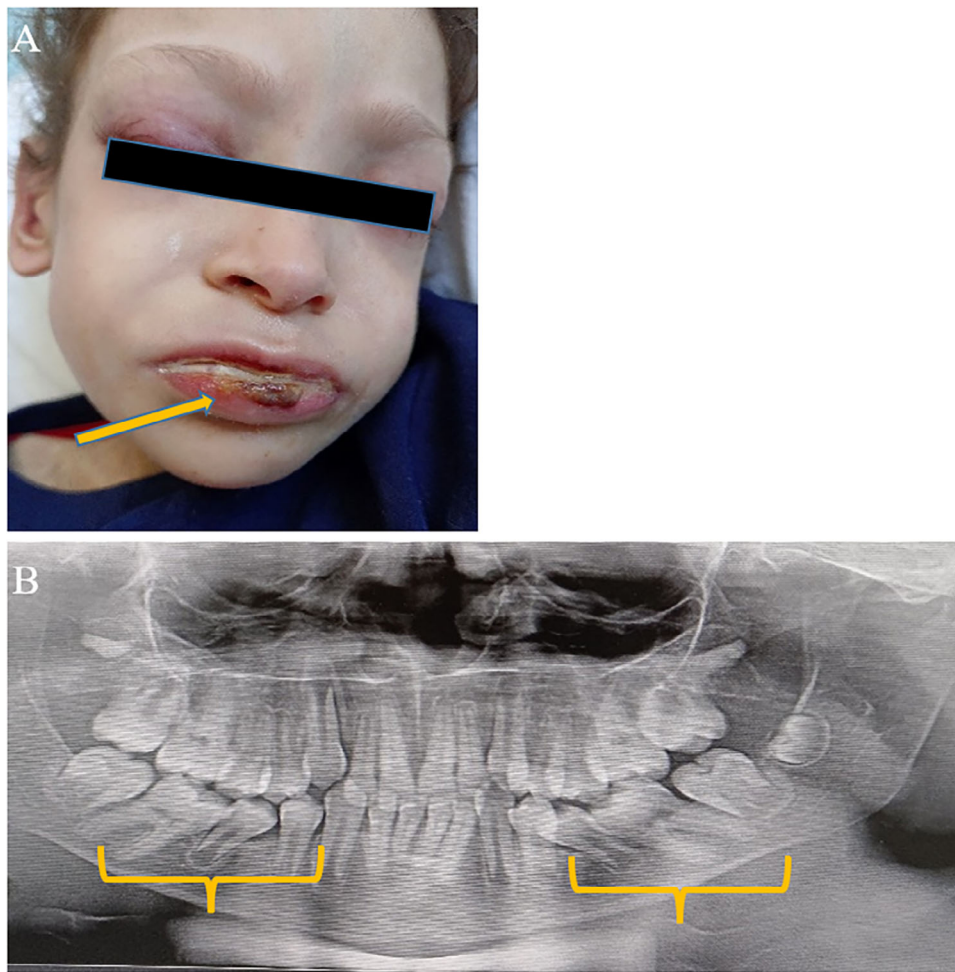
Oral complications in a patient with congenital neutropenia. A 9-year-old male adopted child with congenital neutropenia due to an unidentified cause was first noted to have an ANC less than 500 at 1 year of age. Despite treatment with G-CSF, his granulocyte count has not increased. (A) Severe, chronic lip (arrow) and oral ulcers (unable to show) have impaired his ability to open his mouth for eating and drinking. (B) Panoramic dental x-ray. Dentition status: Presence of a complete permanent dentition, which appears premature for the patient's age. Caries risk assessment: No radiographic evidence of dental caries is present, likely attributed to the patient's history of PEG tube feeding, which reduces direct food contact with the oral cavity, thus minimizing caries risk. Occlusion analysis: Malocclusion is evident (indicated by braces), notably affecting the premolars. Contributing factors may include premature loss of primary molars and abnormal eruption patterns, potentially due to underlying systemic health conditions. Used with permission from the patient's legal guardian.
